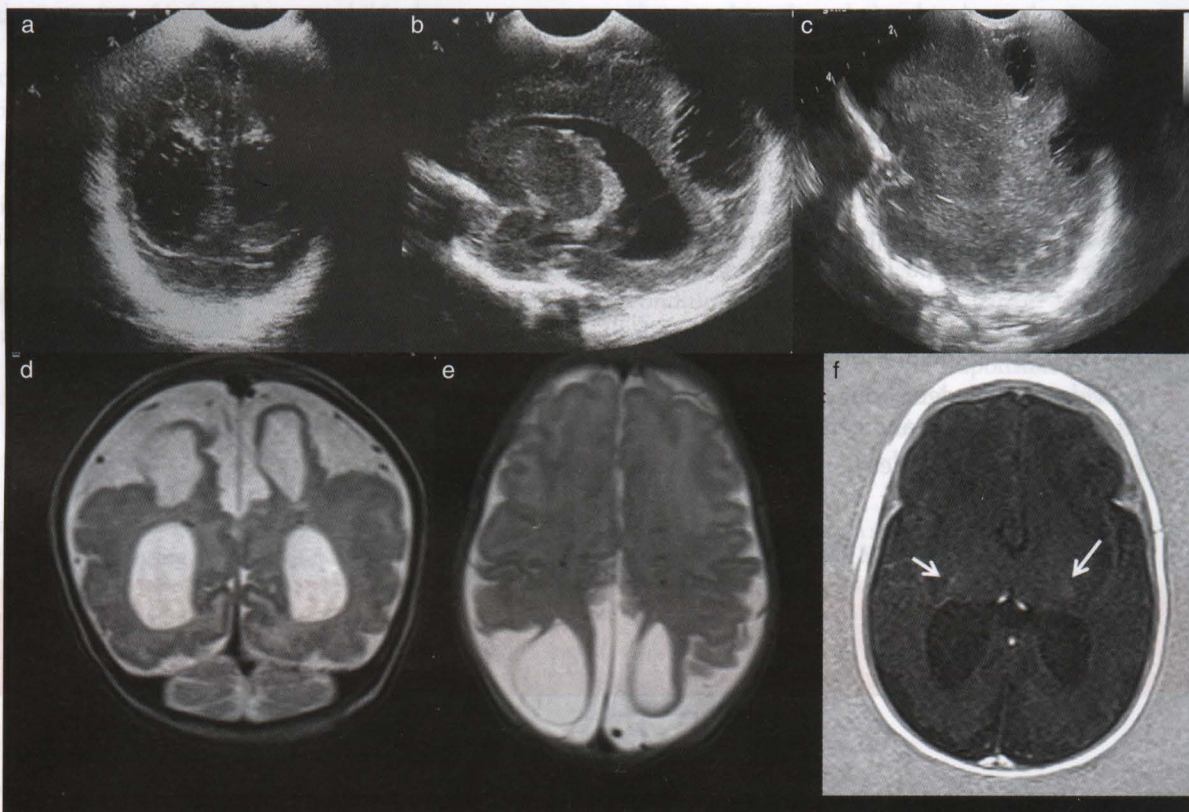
Cranial ultrasound day 35, showing the large multiple subcortical and cortical cysts on the (a) coronal and (b–c) right side sagittal views. Brain magnetic resonance imaging at term equivalent age, three Tesla Scanner, Verio: T2-weighted images showing extensive bilateral parietal subcortical and cortical cysts on (d) coronal, (e) transverse, and also frontal (not shown here) and transverse inversion recovery showing slight ventricular dilatation and (f) weak signal of the posterior limb of the internal capsula (white arrows).
